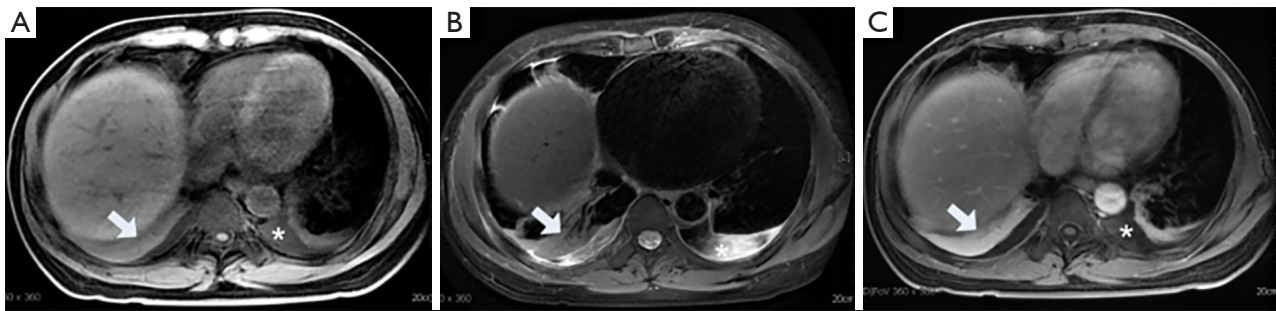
A 72-year-old male with acute pancreatitis complicated with pneumonia and pleural effusion underwent an MRI examination 5 days after onset. The T1WI (A) and T2WI (B) show iso-intense flakes (representing pneumonia) in the bilateral lower lung (arrows), which were enhanced after an administration of contrast agent (C, arrow). On the T2WI (B), the bilateral pleural effusion shows hyperintensity (asterisk). MRI, MR imaging.
